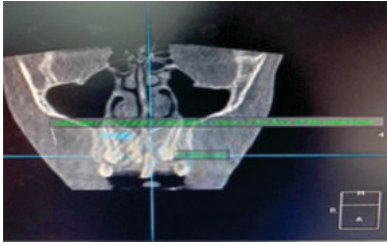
CBCT of the patient.
